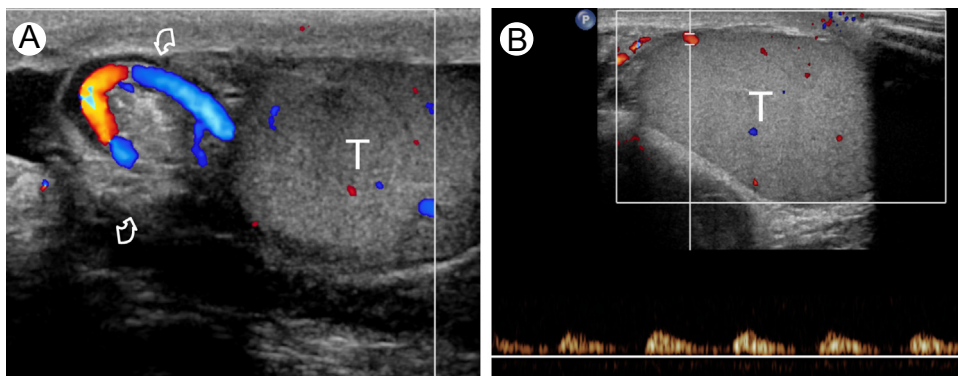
Low-degree testicular torsion. (A) Color Doppler interrogation of the spermatic cord shows vessels with whirlpool course at the level of the twisting of the spermatic cord (curved arrows) consistent with low-degree torsion. (B) Spectral Doppler analysis shows high resistance flows. T: testis. (Color version of figure is available online.)
